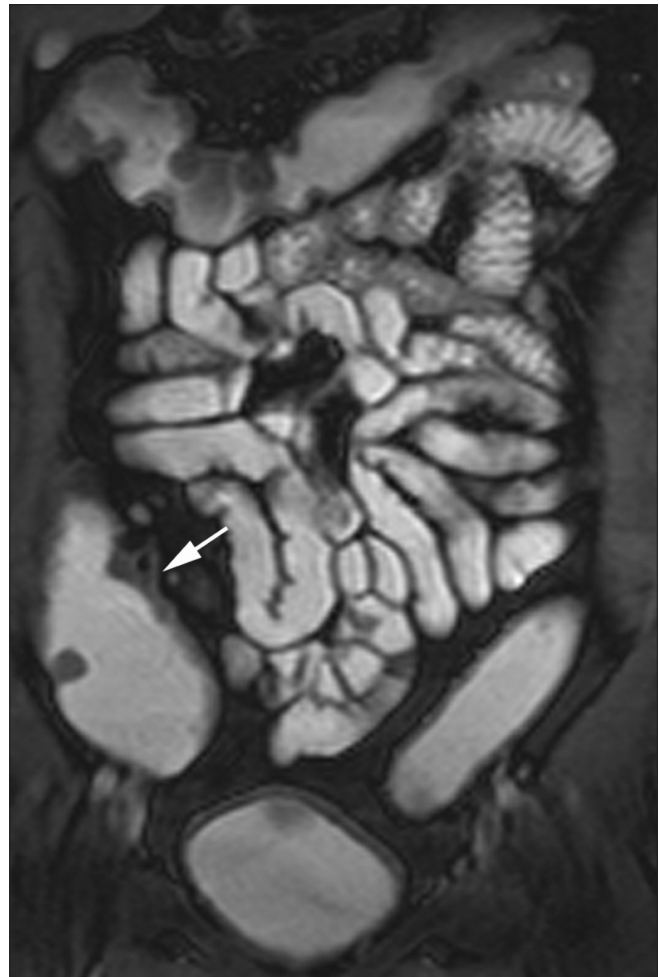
A patient with Crohn disease. MRI enterography examination shows good opacification of the small and large bowel with thickening of the inflamed cecal wall (arrow)
